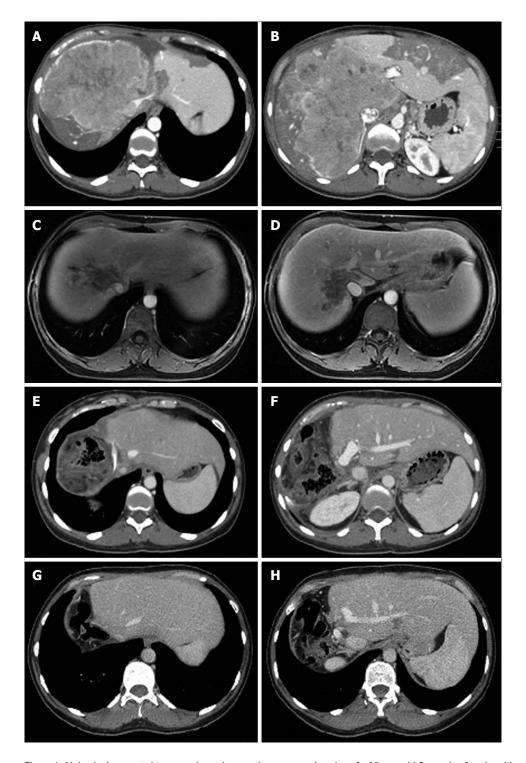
Abdominal computed tomography and magnetic resonance imaging of a 35-year-old Caucasian female, with no previous history of liver disease, showing a large mass in the upper right quadrant. A, B: Abdominal computed tomography (CT) before chemotherapy showing a large mass invading (17 cm × 15 cm) the right and the middle hepatic veins, and surrounding the left hepatic vein; C, D: Abdominal magnetic resonance imaging after gemcitabine-oxaliplatin chemotherapy showing significant reduction of the tumor size; E, F: Abdominal CT two weeks after surgery with hypertrophy of the left lateral segment of liver (liver remnant), and free and patent left branch of the portal vein and left hepatic vein; G, H: Late follow-up after 14 mo.
